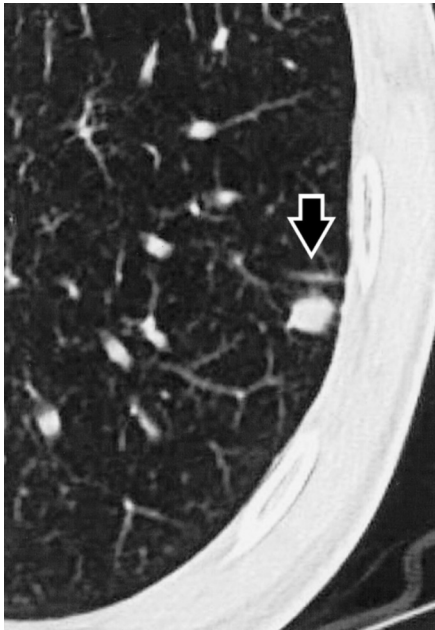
Intrapulmonary lymph node in a 55-year-old man. The thin-section CT scan shows an angular nodule measuring 5 mm in diameter in the left lower lobe. Linear density (arrow) near the lung parenchyma of the intrapulmonary lymph node is evident, and is considered to be thickened interlobular septa.
